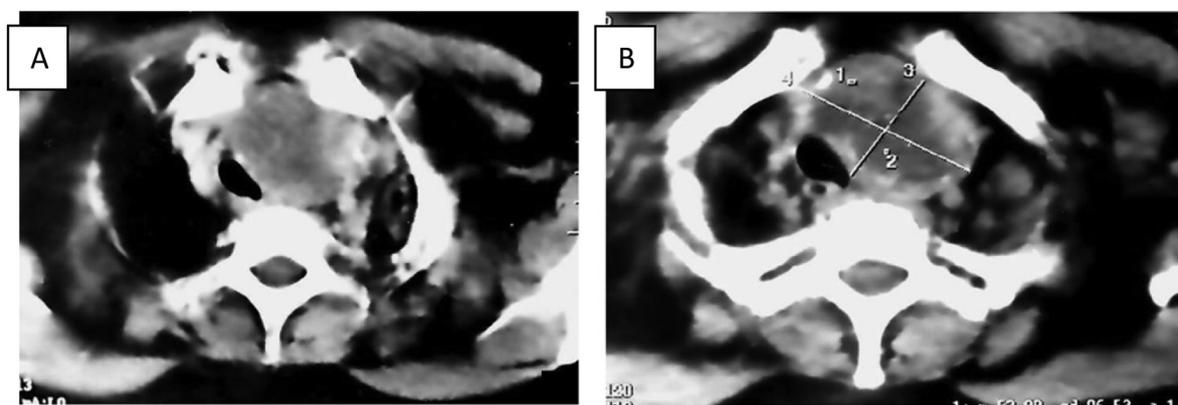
A and B: CT of the neck, showing an oval peripherally enhancing lesion with central non enhancing necrotic region in pretracheal and left paratracheal region, causing right sided displacement and partial intrathoracic compression of trachea between T2 to T4 levels in the superior mediastinum.
